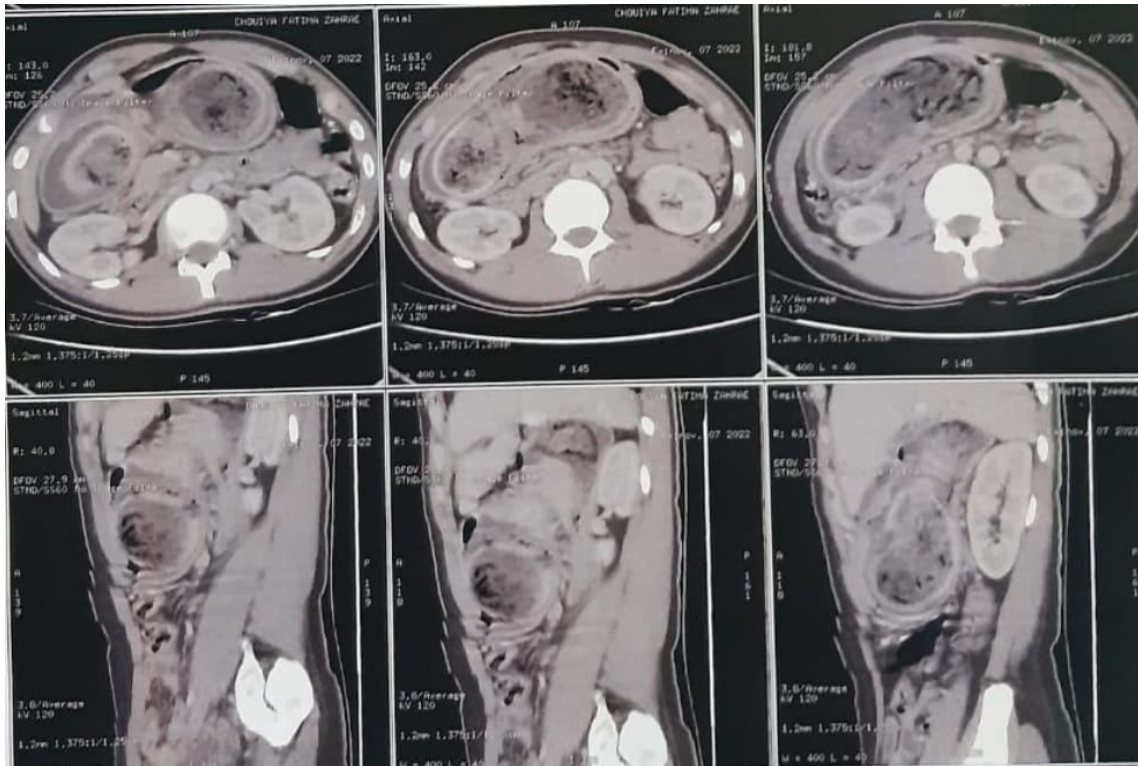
Abdominal CT in axial and longitudinal section after IV injection of the contrast product.
